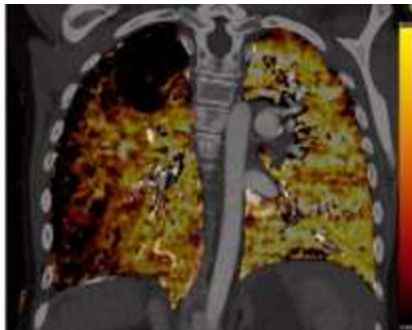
Axial CT of the chest. Iodine distribution and vascular overlay displaying perfusion differences. The left upper lobe demonstrates decreased relative perfusion (white arrow) due to a lobular pulmonary embolism (open arrow).
